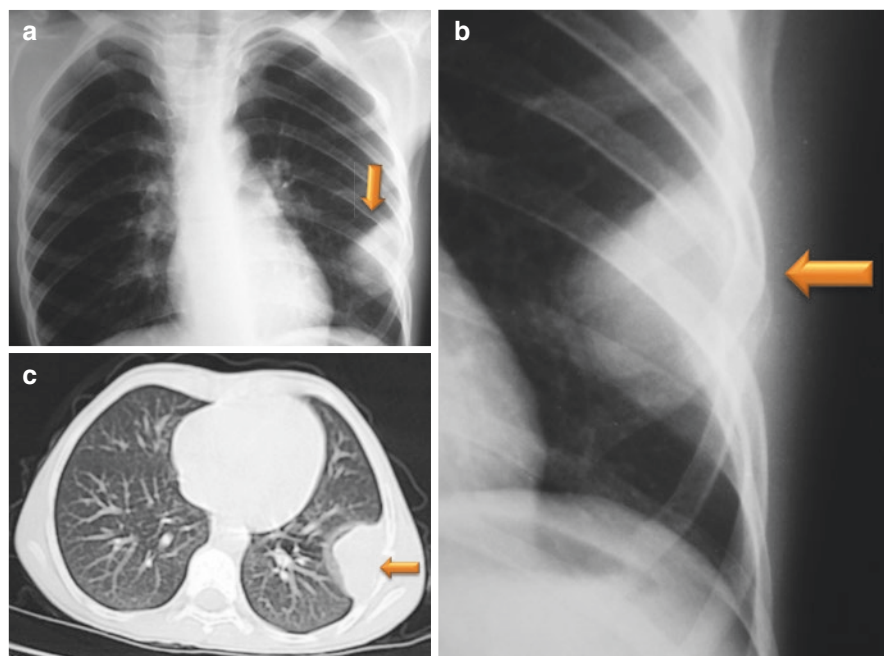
(a–c) Chest x-rays and CT-Scan showing Askin’s tumor of the chest wall (Askin’s tumor is a primitive neuroectodermal tumor developing from the soft tissues of the chest wall)
